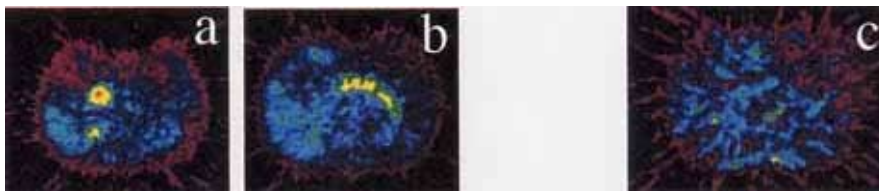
a,b: Pretreatment FDG PET images, demonstrating diffuse and high accumulation in the pancreas, which could not deny malignancy. c: FDG PET image after starting steroid therapy, showing no FDG accumulation in the pancreas.
